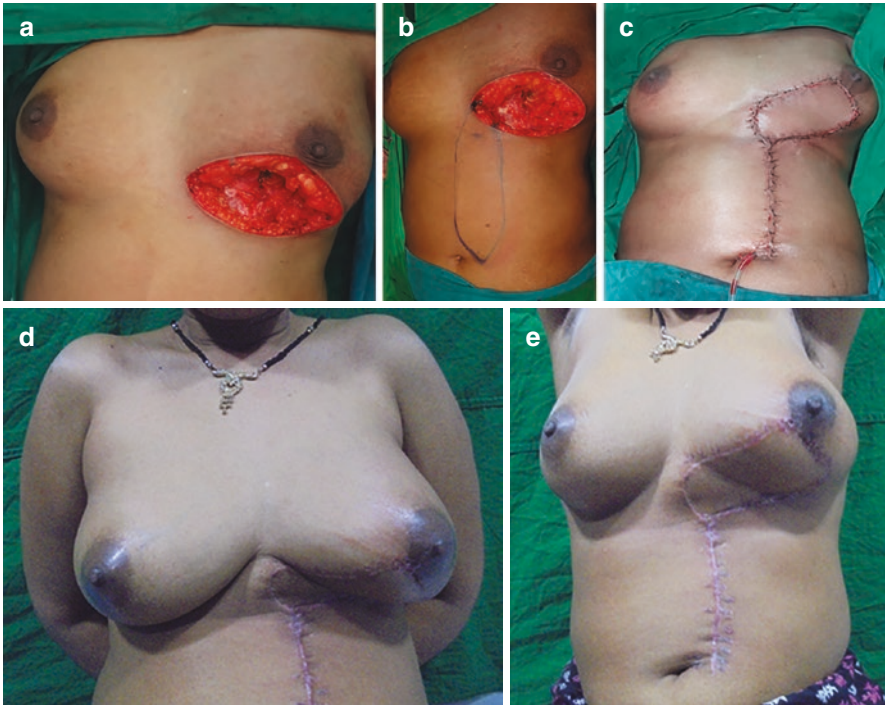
SEAP flap, (a) Lower inner quadrant defect with injured LD pedicle (clock wise), (b) Flap planned around a robust audio Doppler signal and perforator visualisation from the defect, (c) flap harvested, inset with donor site primary closure, (d and e) Follow up after radiation
